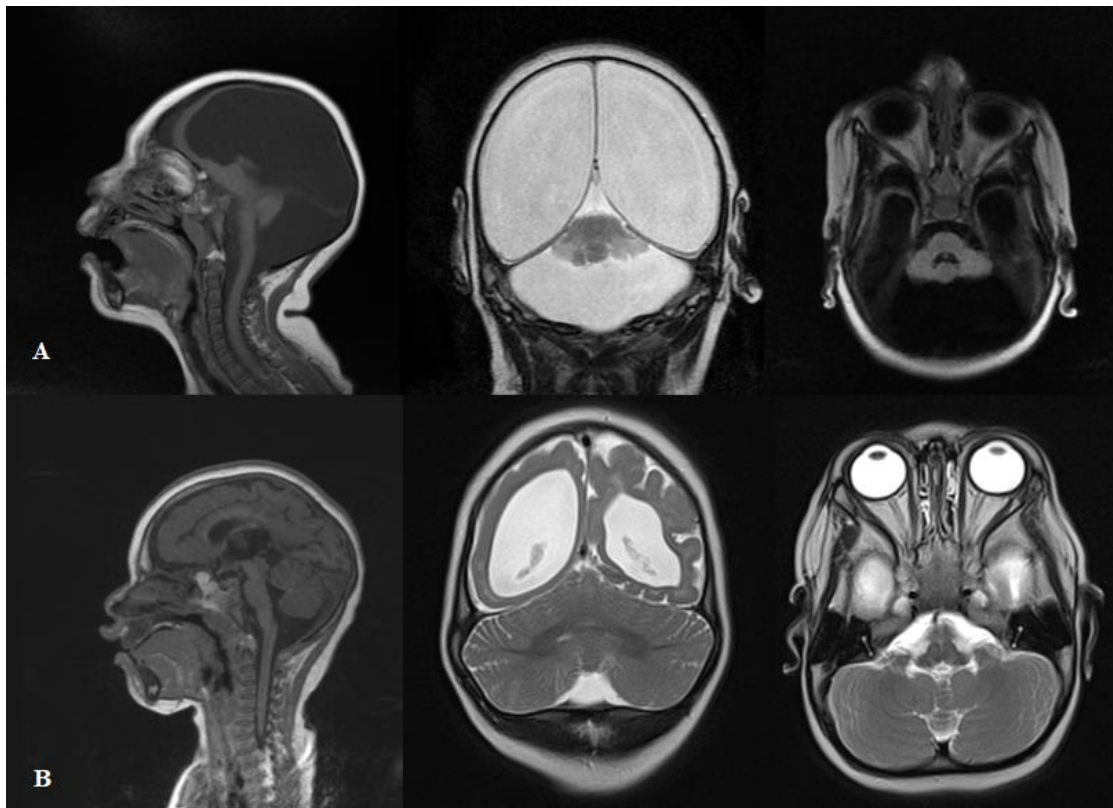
MRI of two children with CZS (from left to right sagittal, coronal and transversal views). A: Severe Infratentorial Abnormality (severe hypoplasia of cerebellum, vermis cerebelli and brainstem). B: Absence of severe infratentorial Abnormality.
